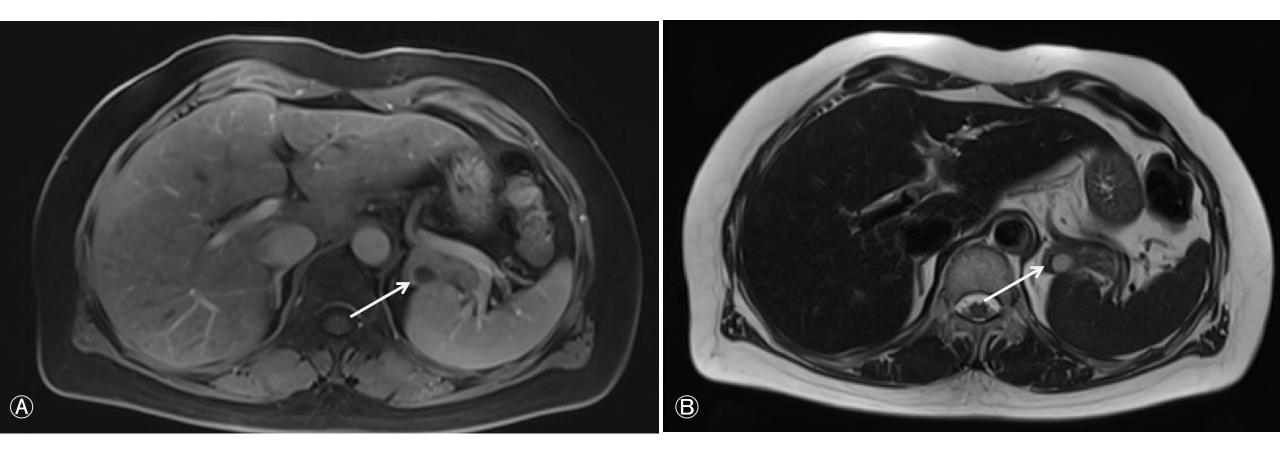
(A) Contrast-enhanced, fat-saturated T1-weighted image demonstrates a cystic lesion with peripheral enhancing component in pancreas tail (white arrow). (B) Enhancing portion of the mass shows hypointense on T2-weighted image (white arrow).
